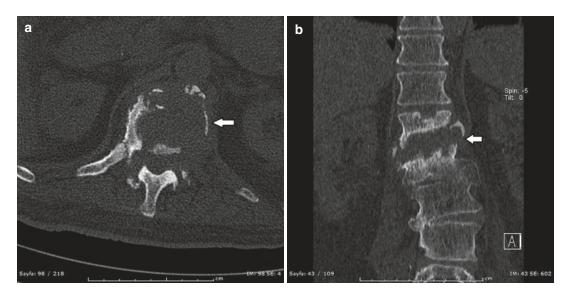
A 67-year-old man. Axial (a) and coronal (b) CT images demonstrate lytic bone destructions of the vertebral body (*arrow*) with an adjoining soft tissue abscess
